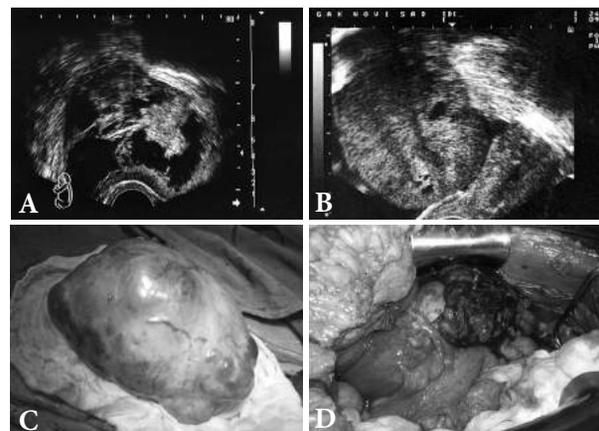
A and B – characteristic ultrasonography images of ovarian cancer with intracystic proliferations and solid portions; C – serous cystadenocarcinoma FIGO stage IB (low grade); D – intraoperative finding of pelvic organs infiltration FIGO stage IIIC
